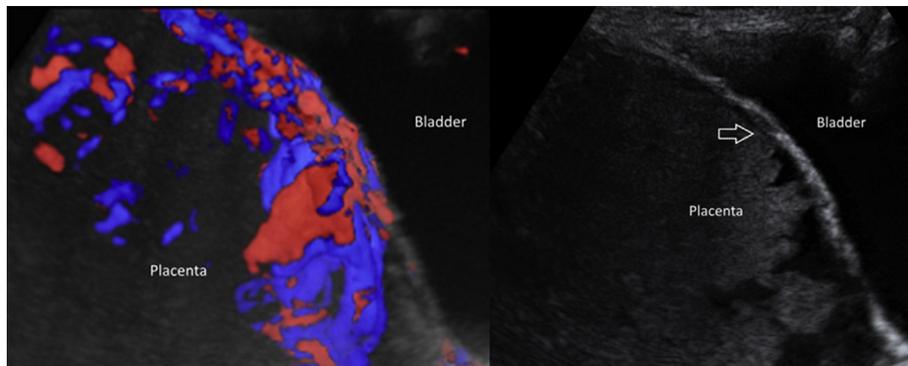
absent placental-bladder interphase (arrow) is a sign of abnormally invasive placenta. Increased vascularity in the placenta-bladder interphase in 3D ultrasound.
